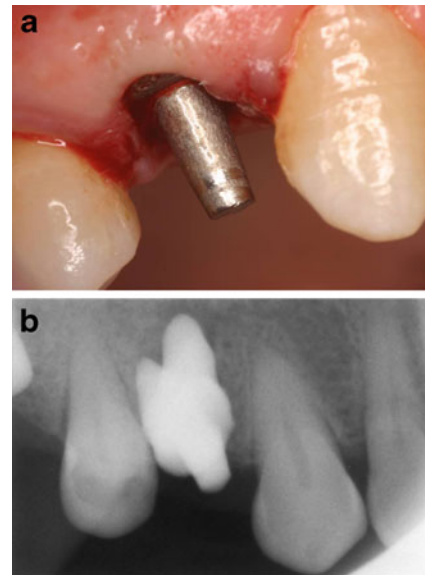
a The custom-made RAI immediately after insertion in the fresh alveolar socket. b Post-operative x-ray. Note the perfect correspondence between the RAI and the post-extraction socket
